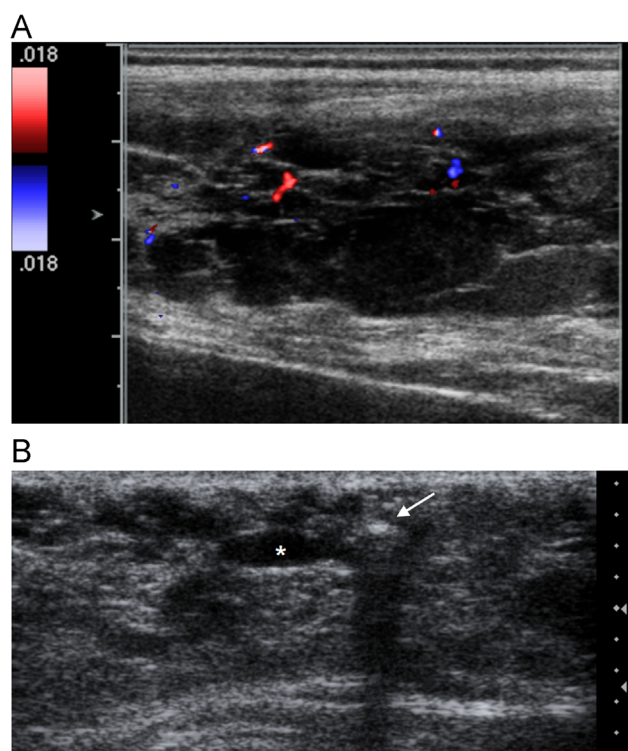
Ultrasound images showing echogenic debris and phleboliths. (Color version of figure is available online.)
